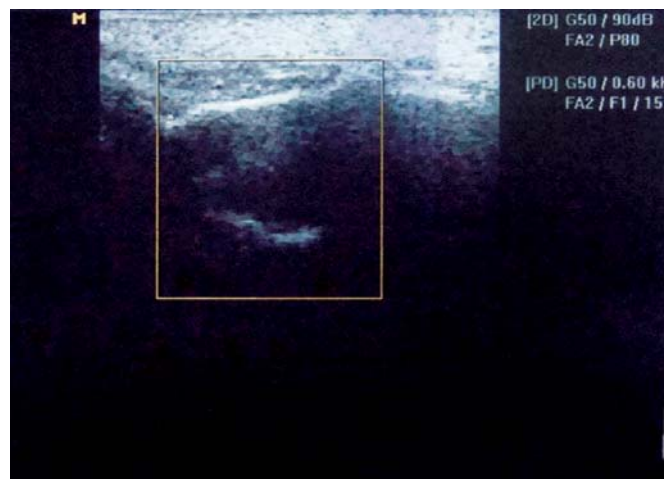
Case 2—ultrasonogram in 21, 22 region
